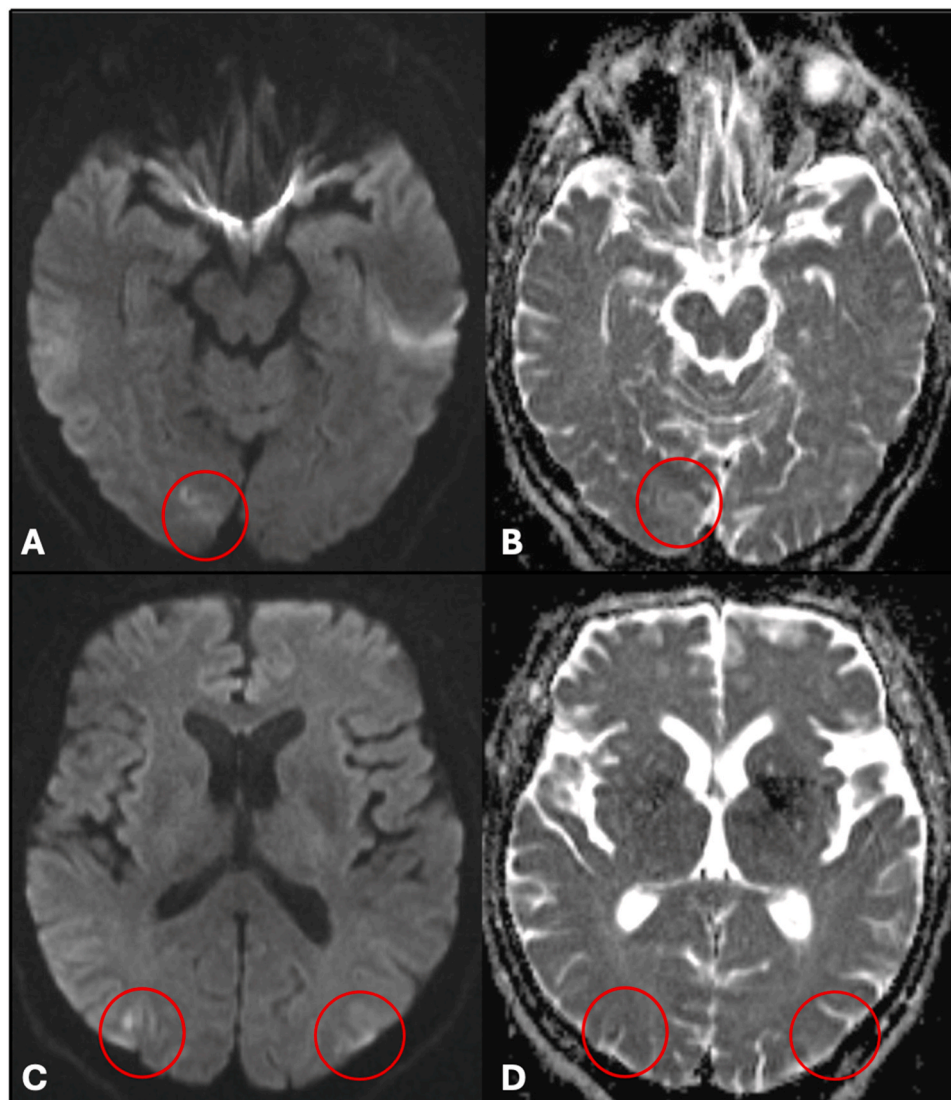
MRI axial slices, DWI (A,C) and ADC (B,D) sequences demonstrating diffusion restriction in the right medial occipital lobe (A,B) and bilateral inferior parietal lobules (C,D).
